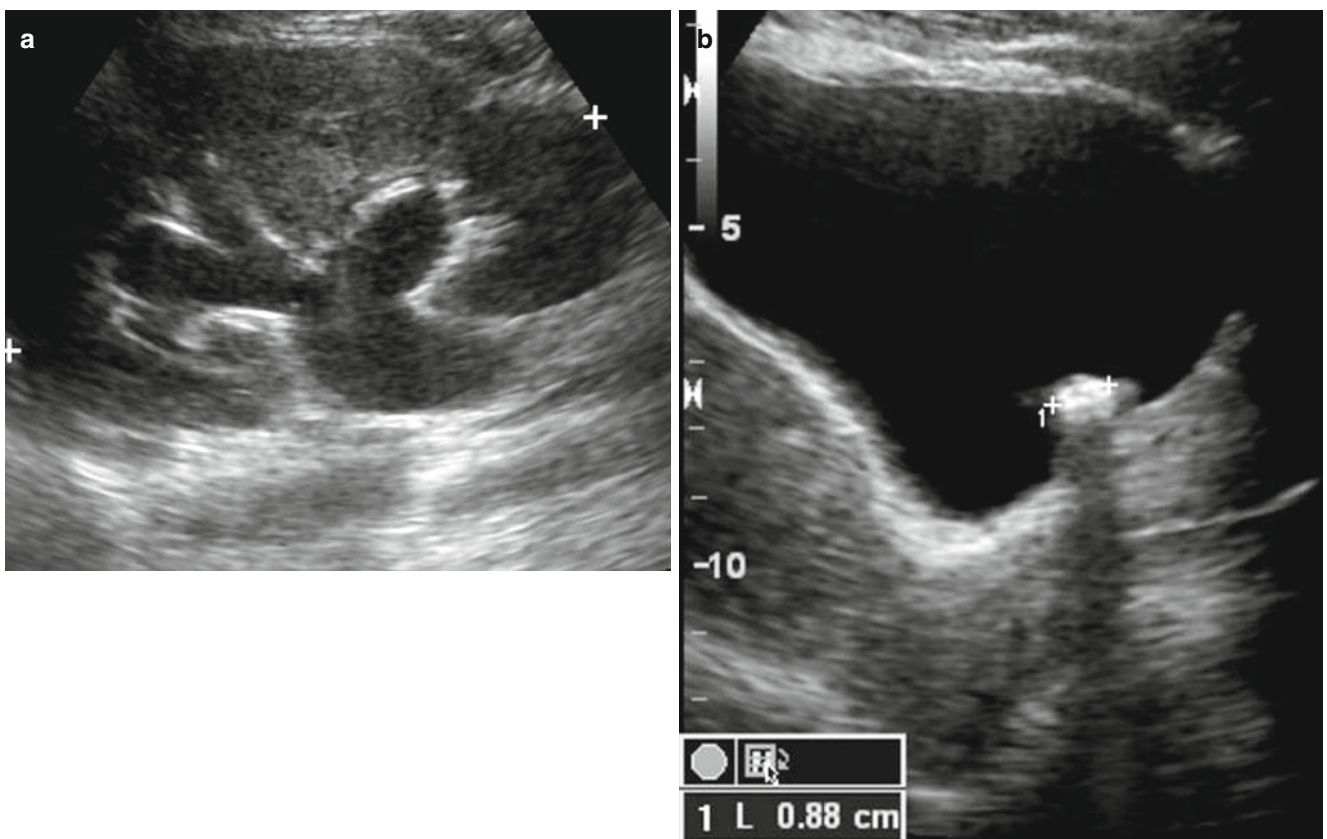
Obstructing left UVJ stone with upstream left hydronephrosis. Ultrasound images show moderate left hydronephrosis (a). Shadowing echogenic focus at the left UVJ is consistent with obstructing stone (b)
